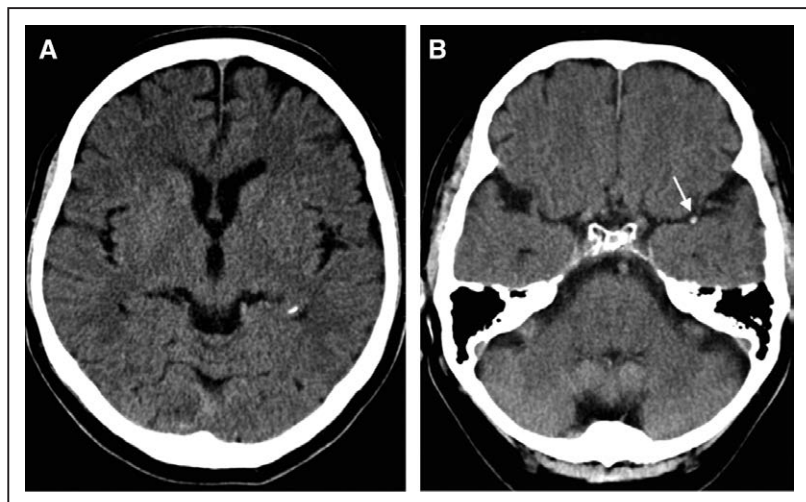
Noncontrast computed tomography (CT) in patient with left middle cerebral artery occlusion. A, High Alberta Stroke Program Early CT Score (ie, minimal ischemic damage). B, Hyperdense artery sign (white arrow).
